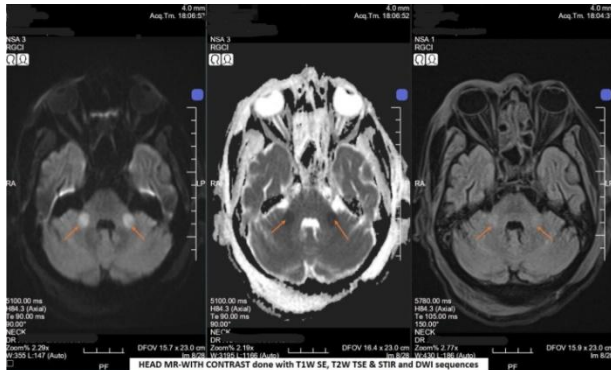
MRI brain showing bilateral middle cerebellar peduncle changes consistent with extrapontine myelinolysis.
